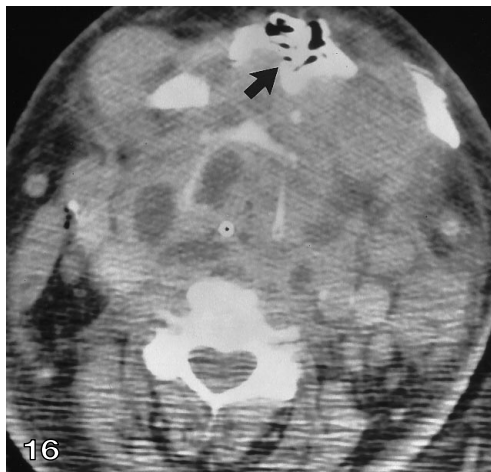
A contrast-enhanced CT scan of the neck in a patient with midline erythema, tenderness, and swelling demonstrates a midline mass with central low attenuation and a thick, irregular, enhancing rim. Cellulitic changes are noted in the overlying skin and subcutaneous fat. The patient was treated with intravenous antibiotics, and when the acute inflammation had resolved, a thyroglossal duct cyst was resected
